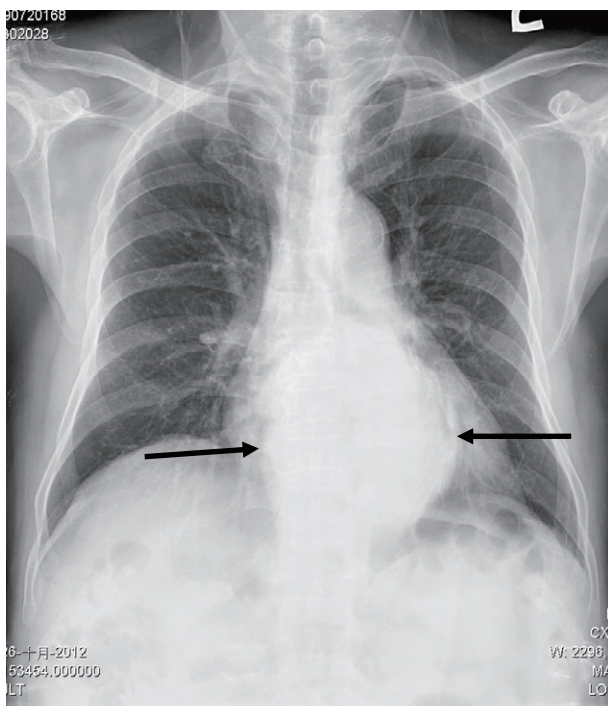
Chest x-ray revealed a prominent round mass opacity at the lower mediastinum (arrows).
